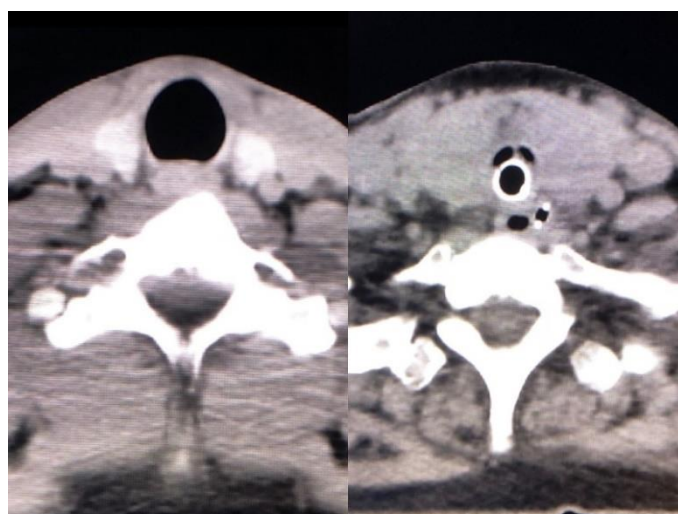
Thyroid gland on computed tomography. A normally functioning thyroid shows high density compared with the surrounding tissue (left). Under conditions of hypothyroidism, the thyroid gland shows low density and loses contrast with the surrounding tissue (right).
